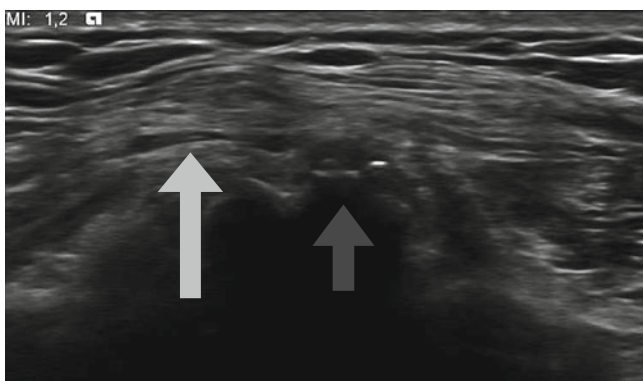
Ultrasound of the lateral cutaneous nerve in a patient with meralgia paresthetica. *Left arrow* points to a “thickened” nerve, *right arrow* points to the anterior iliac crest (*black*)
